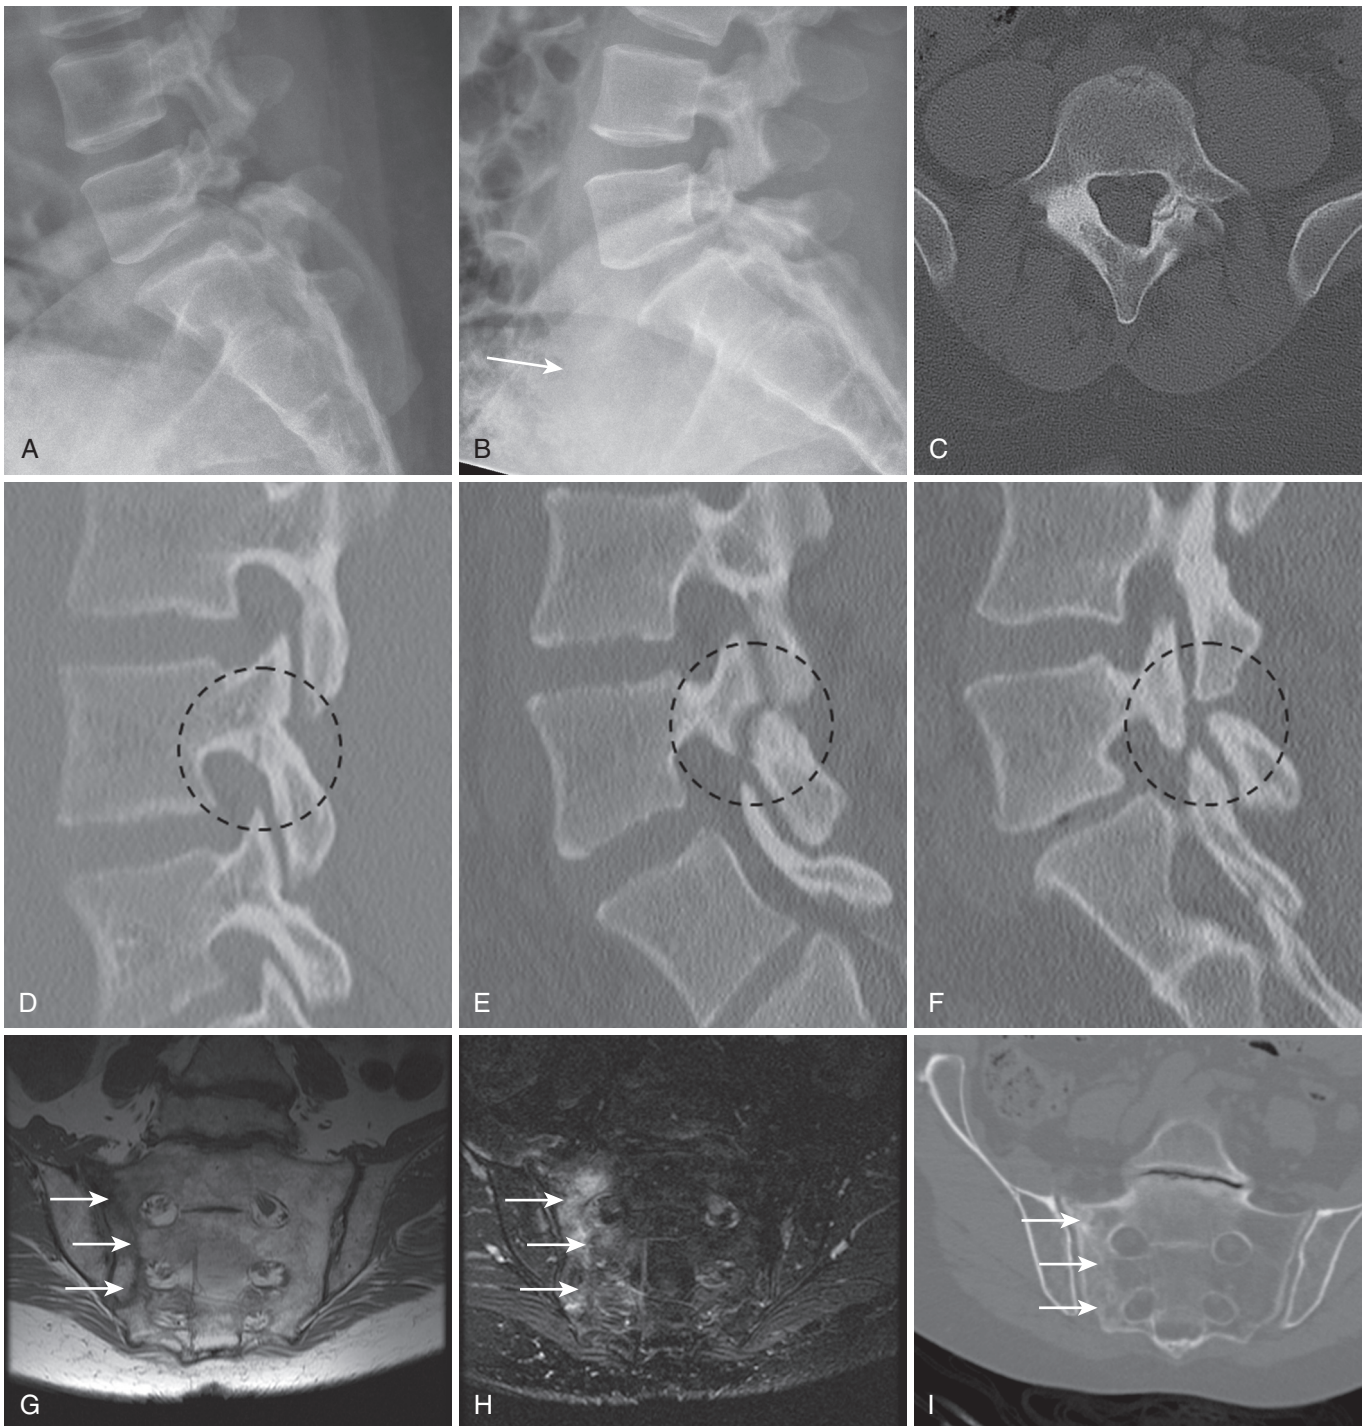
Stress fractures. Spondylolysis at L5 is visible on flexion (A) and extension (B) radiographs. Although there is no translation of L5 on S1, the degree of rotation (12 degrees) qualifies this as unstable. In unilateral spondylolysis, the contralateral pars often shows hypertrophy and sclerosis (C). CT can be used to stage pars fractures as early stage (D) with a narrow, sharply margined fissure; progressive stage (E) with a narrow fissure having slightly rounded margins; and terminal stage (F) with a wide fissure with rounded margins and sclerosis. Typical sacral stress fracture (*arrows*) demonstrates a low signal fracture line on a coronal T1 image (G), a linear zone of T2 hyperintensity on a STIR image (H), whereas CT demonstrates a linear zone of sclerosis (I). The integrity of the neural foramina is better defined on CT. (From Murthy NS. Imaging of stress fractures of the spine. *Radiol Clin North Am.* 2012;50:799-821.)
